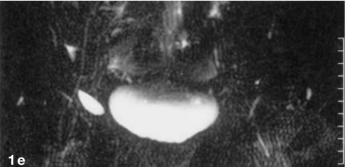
e. Indirect right-sided hernia in a 66-year-old man. a Herniography; b T1-weighted axial MR image shows the hernia filled with fat (arrow); c Fat-suppressed inversion recovery (STIR) image at the same level as b shows the hernia filled with fat (arrow); d T1-weighted coronal MR image shows the hernia filled with fat (arrow); e Magnetic resonance cholangiopancreaticography (MRCP) image resembles the herniography. Patient is in prone position
